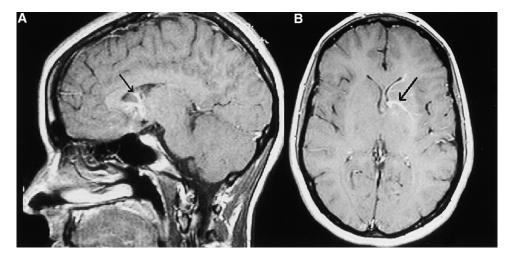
Venous angioma. (A) Sagittal view: T1-weighted postcontrast image. Venous angioma is seen (*arrow*). (B) Axial view: T1-weighted postcontrast image. Venous angioma is seen (*arrow*).
